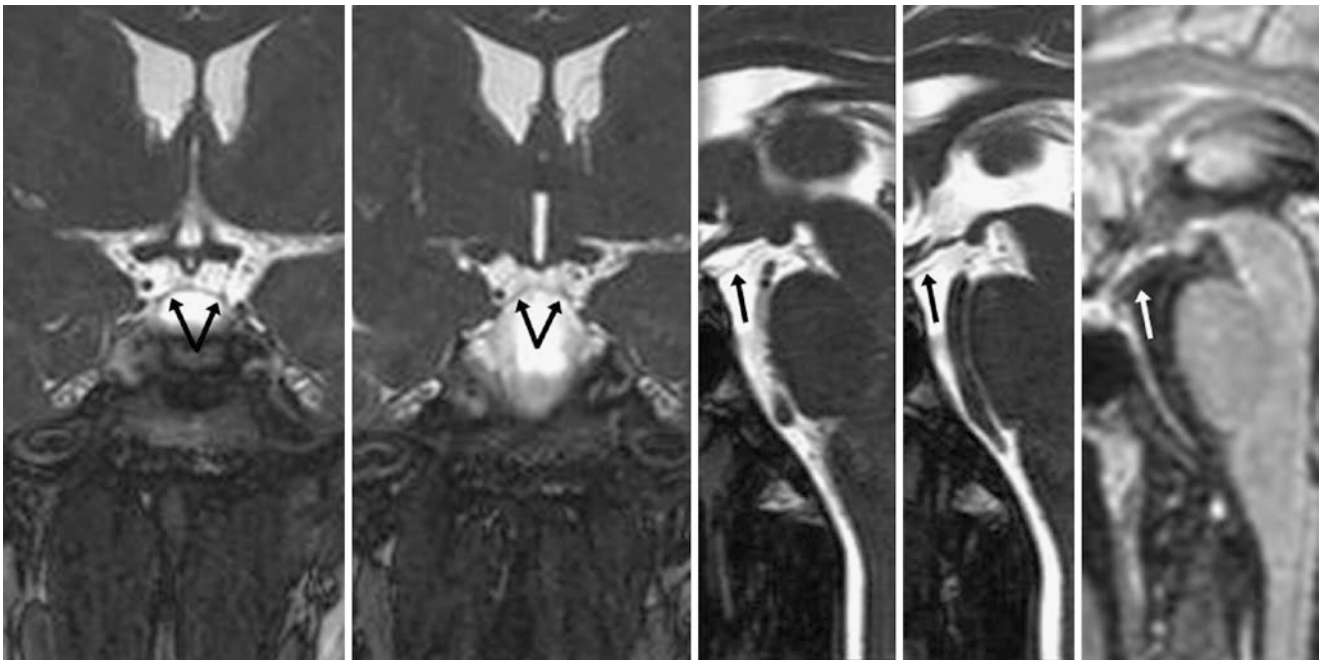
A 29-year-old patient with an incidental LM (*arrows*) on a negative MRI obtained for ear infections. The LM attaches to the dorsum sellae anteriorly, as delineated on three-dimensional reformatted
